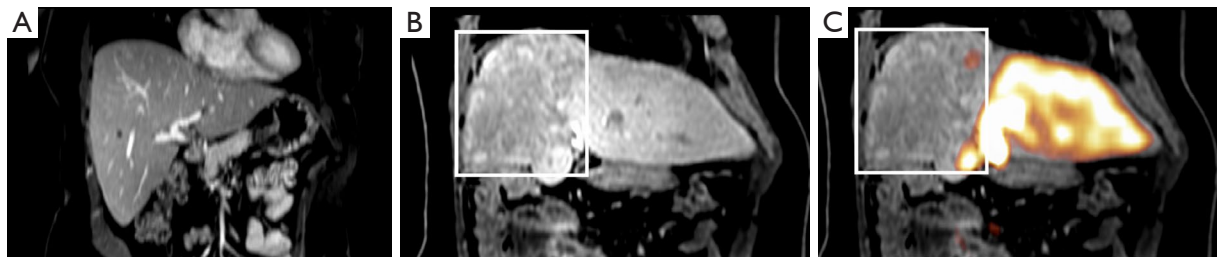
Post contrast MRI prior to neoadjuvant right lobar TARE demonstrates a small FLR (A). Hepatobiliary phase MRI post hepatocyte contrast administration obtained 6 months after initial TARE demonstrates FLR hypertrophy and poor biliary excretory function of the FRS (square) (B). FRS devitalization is supported by reduced radiotracer activity (square) using ^{99m}Tc -Mebrofenin MRI fusion (C). TARE, transarterial radioembolization; FLR, future liver remnant; FRS, future resection site.
